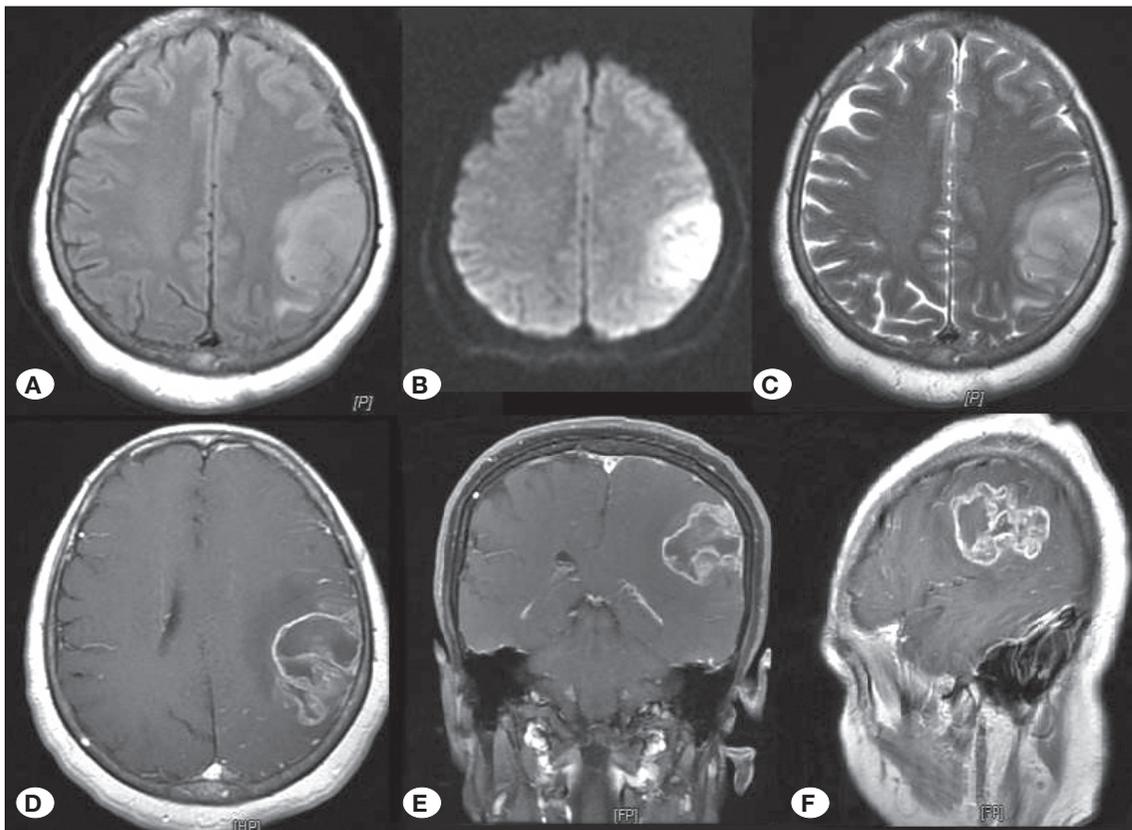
A) Axial section FLAIR section, B) axial section diffusion MRI, C) axial section T2W MRI of the brain. D) 1st month contrast enhanced T1W axial brain MRI, E) 1st month contrast enhanced T1W coronal brain MRI, F) contrast enhanced T1W sagittal brain MRI.
